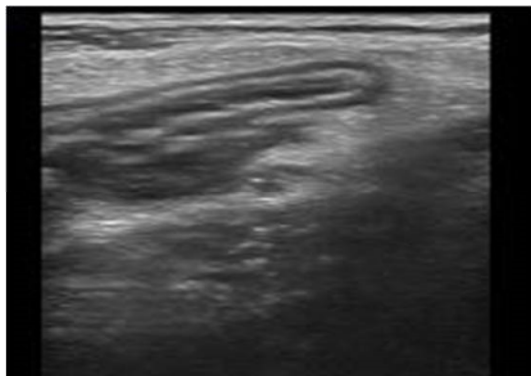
(K-M). Right lower quadrant longitudinal sonogram reveals Perforated Appendix with periappendiceal hypoechoic fluid collection.
